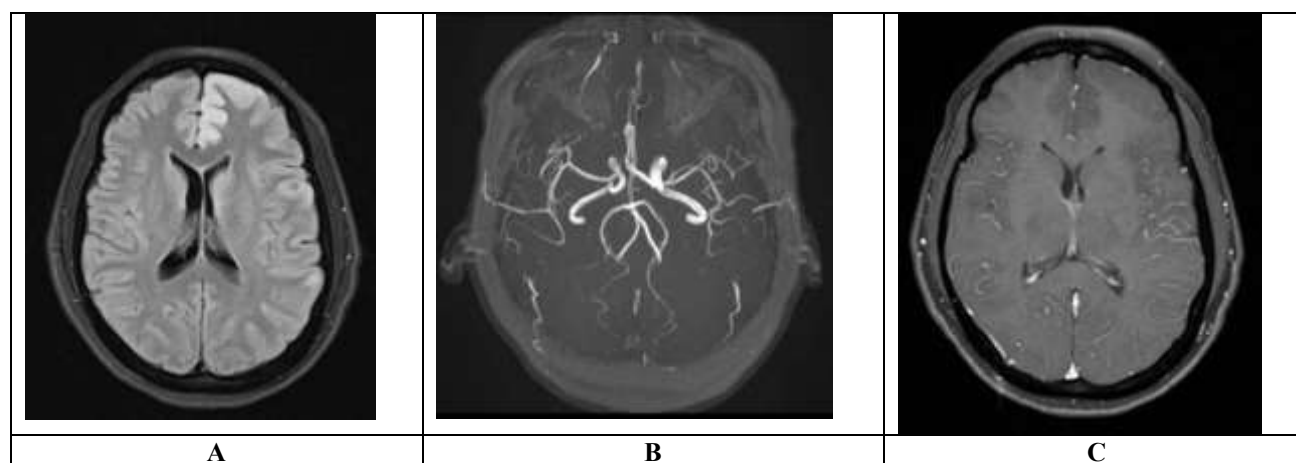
Simple and contrast-enhanced magnetic resonance imaging of the skull
